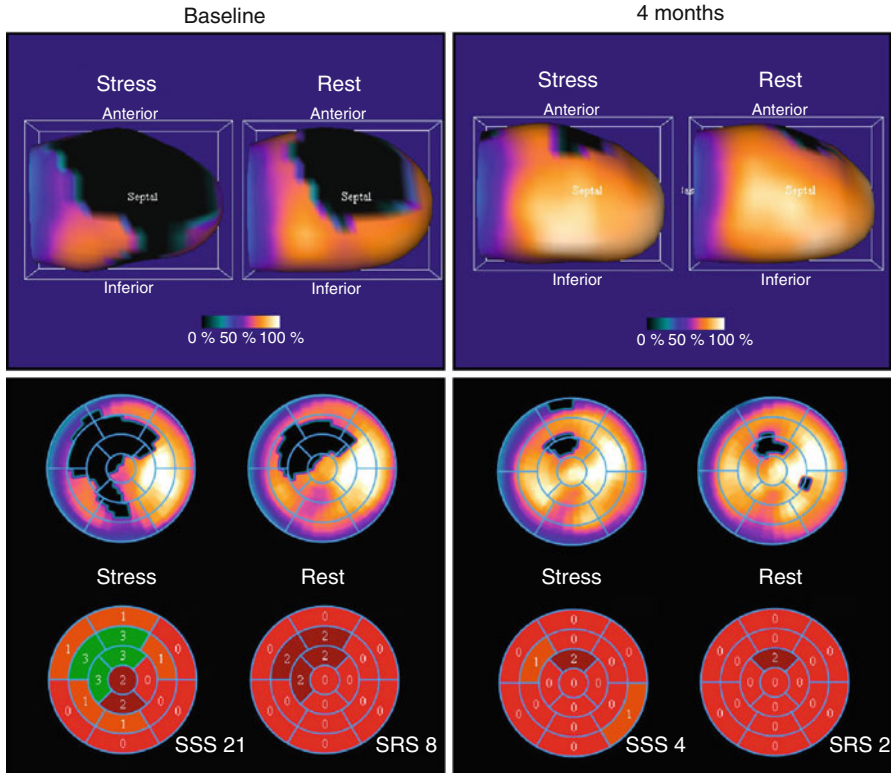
Cardiac SPECT imaging. Technetium-99m sestamibi single-photon emission computed tomography (SPECT) scintigraphy looking at myocardial perfusion. Patient with acute anterior MI presented an important perfusion defect of the anteroseptal and apical territories (*top left*). The bull’s-eye image (*bottom left*) combining the 17 segments revealed an important ischemic territory with summed stress score (SSS) of 21 and a summed rest score (SRS) of 8. The summed difference (SDS = SSS – SRS) was 13 (not shown), indicating a significant redistribution (reversible perfusion defect). Four months later (*rights*), perfusion defect and ischemia were significantly reduced as revealed by stress and rest SPECT (Used with kind permission of Springer Science + Business Media from Mansour et al. [6])
